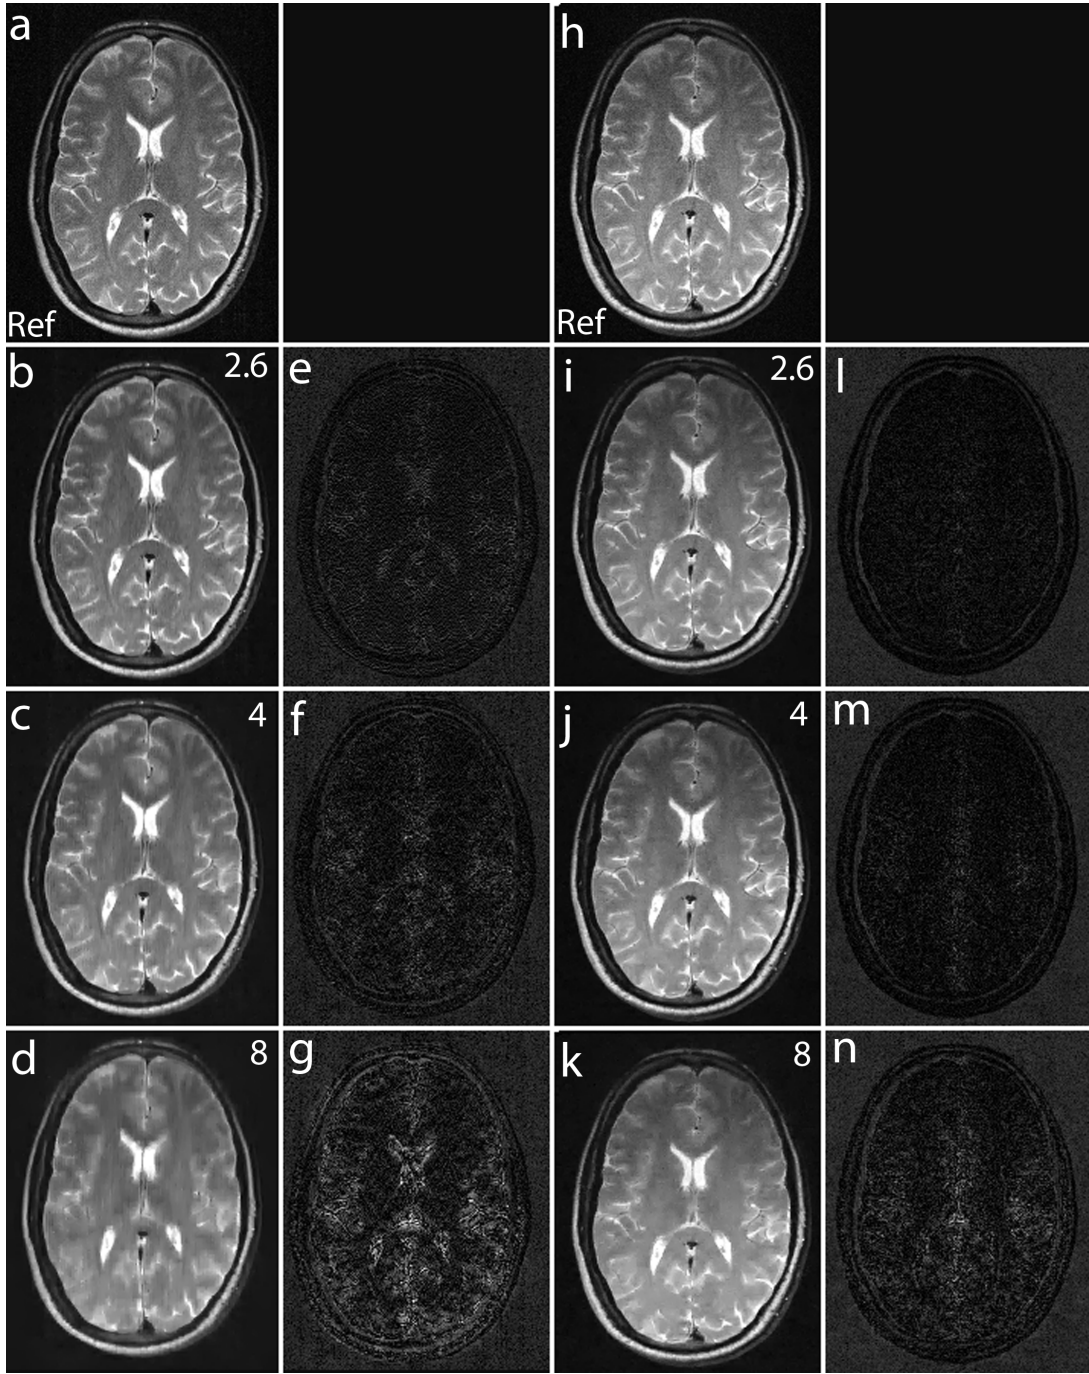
MCS-MRI reconstruction on *in vivo* brain images using acquired noiselet encoded and Fourier encoded data for different acceleration factors (up/down: phase encodes, left/right: frequency encode). (a): shows reference image reconstructed from fully sampled Fourier encoded data; (b)-(d): show images reconstructed using Fourier encoding for acceleration factor of 2.6, 4 and 8 respectively; (e)-(g): show the difference images using Fourier encoding for acceleration factor of 2.6, 4 and 8 respectively; (h): shows reference image reconstructed from fully sampled Noiselet encoded data; (i)-(k): show images reconstructed using noiselet encoding for acceleration factor of 2.6, 4 and 8 respectively; (l)-(n): show the difference images using noiselet encoding for acceleration factor of 2.6, 4 and 8 respectively. It can be seen from the difference images that noiselet encoding outperforms Fourier encoding on the acquired *in vivo* data. The loss in resolution is clearly visible for Fourier encoding at an acceleration factor of 8.
